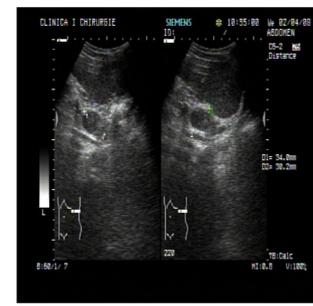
Ultrasound of the left SR after treatment
